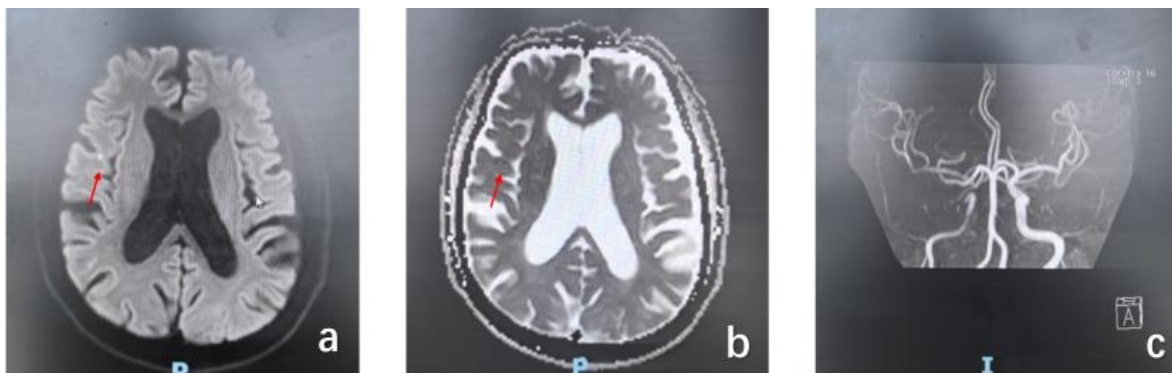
(a) DWI shows a small punctate lesion in the right temporal lobe. (b) ADC value decreases. (c) MRA shows intracranial arteriosclerosis; The intracranial segment of the right internal carotid artery and the middle cerebral artery appear shallower.
